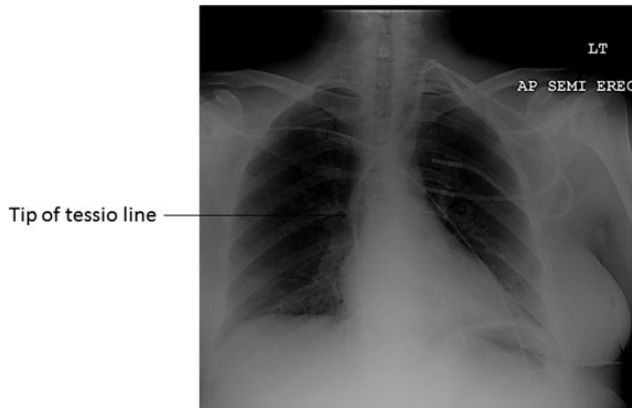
Chest X-ray showing the tip of catheter in the right atrium.
